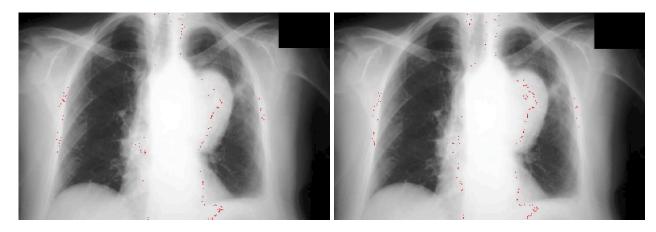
GFA and GCSA recognition over cancer tissues in left part of the lungs on the original image from the X-RAY apparatus
